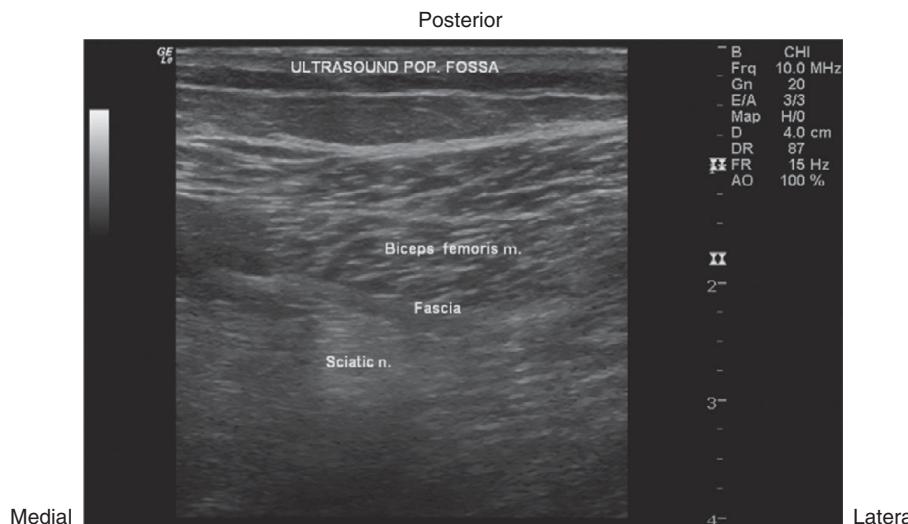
Ultrasound image if sciatic nerve block at the level of the prepopliteal space. Reproduced with permission from Arbona FL, Khabiri B, Norton JA (eds.). 2011. *Ultrasound-Guided Regional Anesthesia: A Practical Approach to Peripheral Nerve Blocks and Perineural Catheters*. Cambridge, UK: Cambridge University Press
